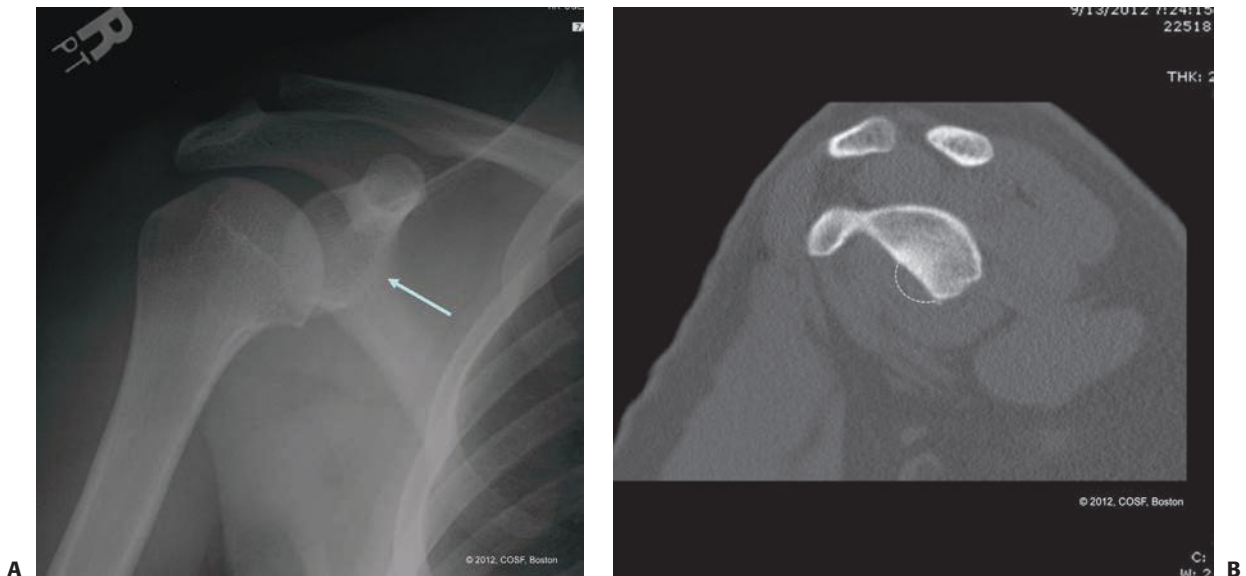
Bony glenoid deficiency in the setting of recurrent anterior instability in a 16-year-old male. A: AP radiograph depicts loss of the sclerotic margin of the anterior glenoid. B: Sagittal CT scan demonstrates loss of the anterior-inferior glenoid. C: Three-dimensional reconstruction further highlights the loss of anteroinferior glenoid bone.
